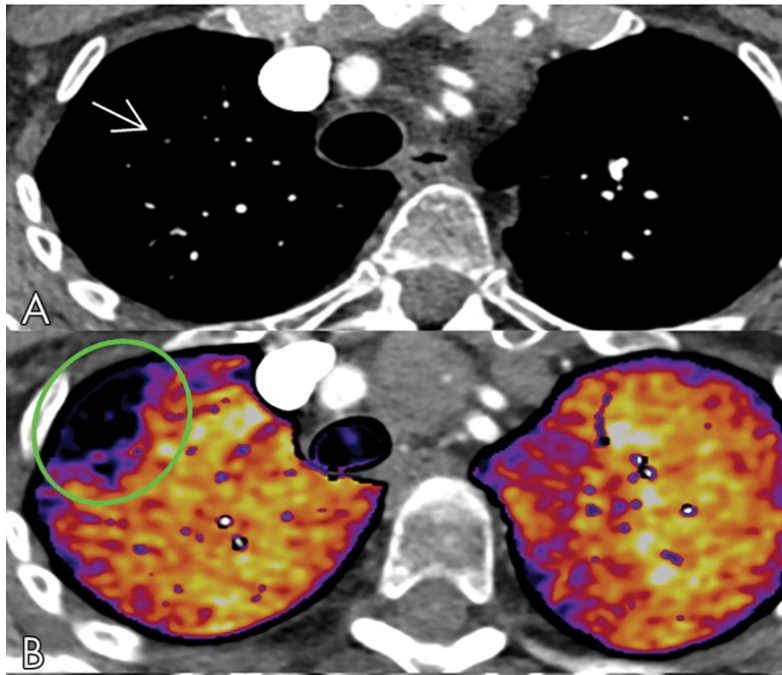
Comparison of standard CT angiography with image subtraction iodine mapping in detecting pulmonary embolus(278).
